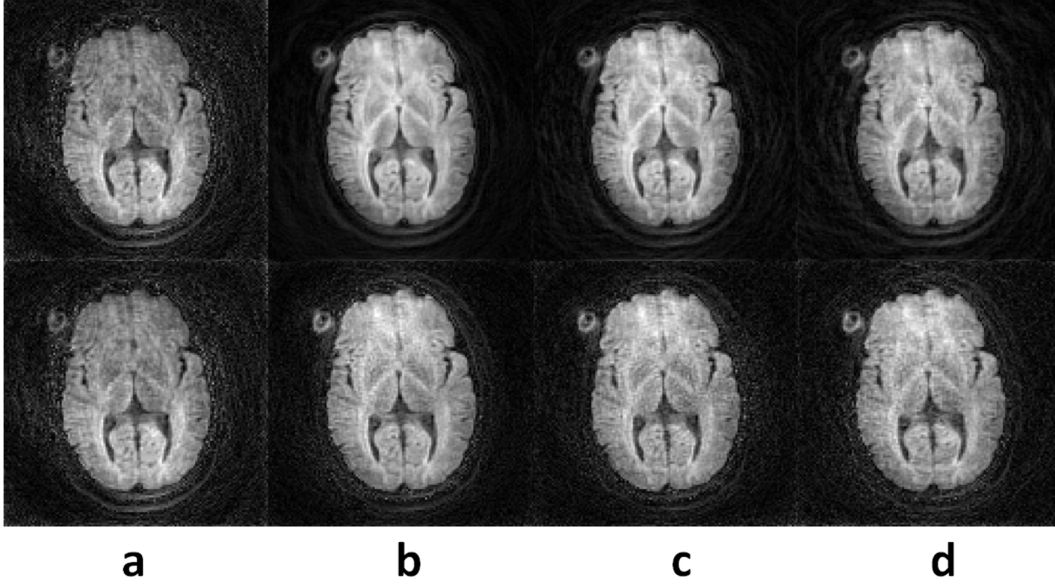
Parallel DWI reconstructed images. (a) Uncorrected SENSE reduction factor of 1 vs. phase correction and SENSE reconstruction of four-channel diffusion-weighted data with (b) reduction factor of 1, (c) reduction factor of 2 , and (d) reduction factor of 2.7. The first and second rows correspond to CG correction and KICT correction, respectively.
